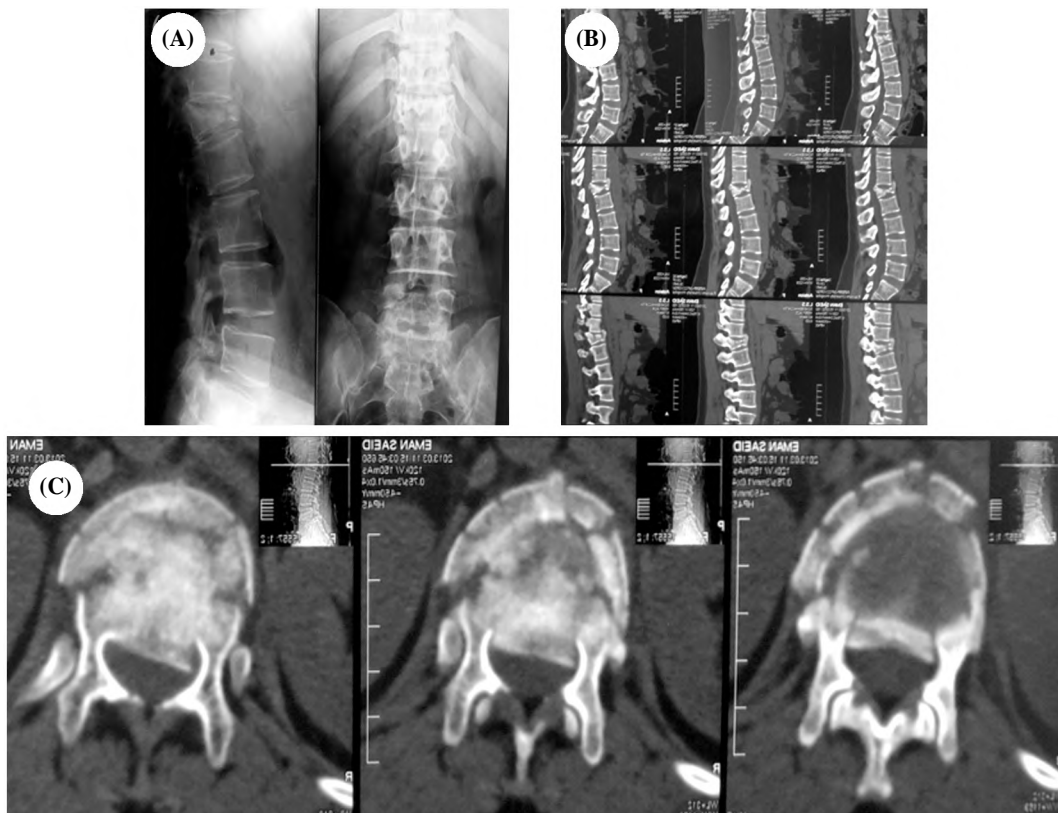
(A) Pre-operative X-ray, (B) Pre-operative sagittal CT scan & (C) Pre-operative axial CT scan indicative of severe comminution of L1 and Cobb's angle 30 degrees.
